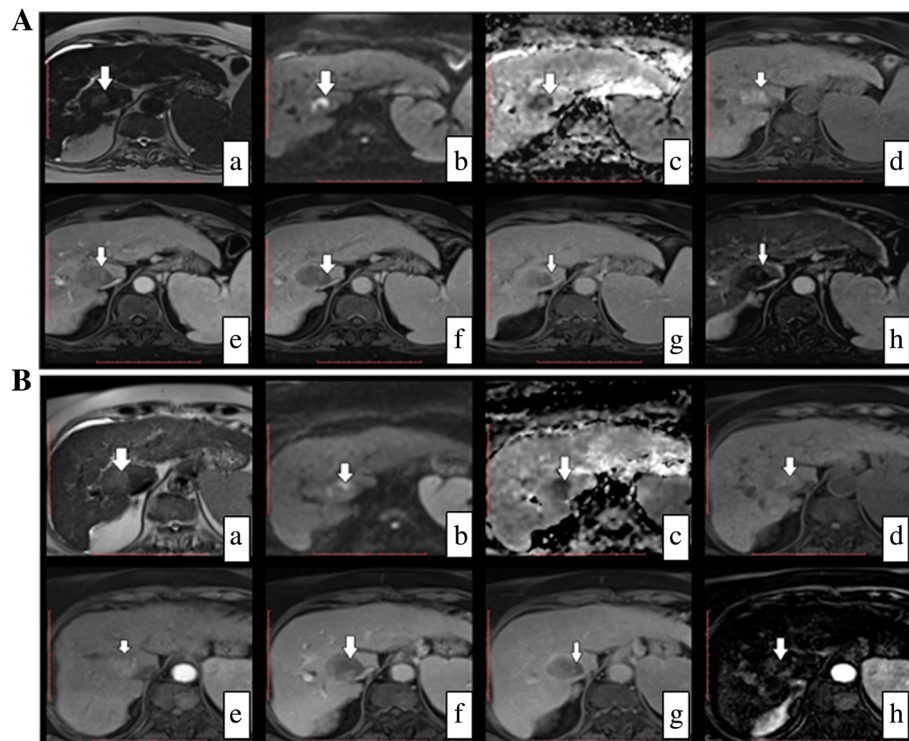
A 64-year-old female patient with hepatitis-related liver cirrhosis and single segment I HCC lesion. She had a TACE session and came for follow up 1 month later. (A) Follow up dynamic MRI 1 month post TACE. a T2WI, b DWI image, c ADC image, d T1WI, e late arterial phase, f Portal phase, g delayed phase, and h late arterial subtracted image. The treatment zone elicits high heterogeneous signal in both T1WIs and T2WIs with the periphery of the lesion is seen of restricted diffusion. NO clear areas of enhancement could be seen in the dynamic study; however, the subtraction images shows faint lesion enhancement (false negative dynamic study interpretation). (B) Follow up dynamic MRI 3 months post TACE. a T2WI, b DWI image, c ADC image, d T1WI, e late arterial phase, f portal phase, g delayed phase, and h late arterial subtracted image. The enhancement became more clear and more appreciated in the dynamic and subtraction images confirming residual/recurrent disease
